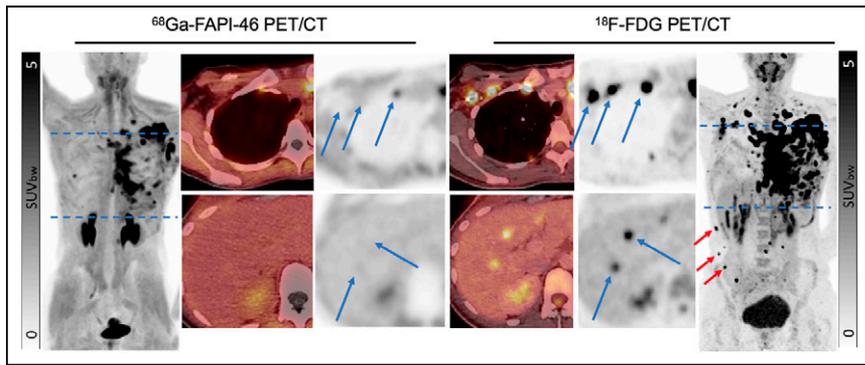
Intraindividual comparison between ^{68}Ga -FAPI-46 PET/CT and ^{18}F -FDG PET/CT for restaging in patient with postoperative left breast cancer (36-y-old woman with large number of metastases). Several metastases to muscles were detectable only on ^{18}F -FDG PET/CT (red arrows). At same axillary level (right side of body), there were 1 and 3 detectable nodal metastases on ^{68}Ga -FAPI-46 PET/CT (SUV_{max} , 3.47; other 2 distal lymph nodes not measurable) and on ^{18}F -FDG PET/CT (SUV_{max} , 26.28, 18.54, and 29.60 from proximal to distal lymph nodes), respectively (blue arrows). In liver region (lower part of images), 2 liver metastases were detectable on ^{18}F -FDG PET/CT (SUV_{max} , 6.65 in segment 4 and 4.50 in segment 5); however, no liver metastases were detectable on ^{68}Ga -FAPI-46 PET/CT (blue arrows). SUV_{bw} = SUV based on body weight.
